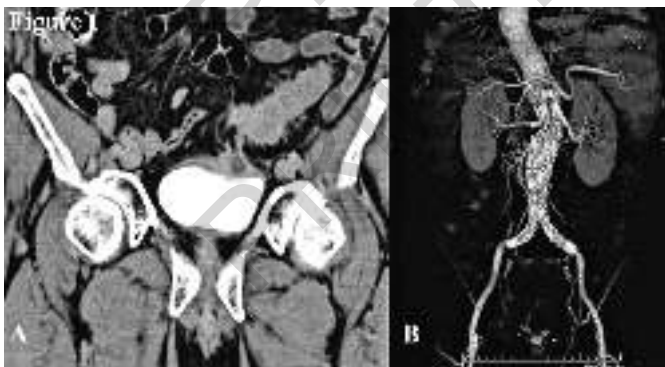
CT-scan of the abdomen showing a sigmoido-vescical fistula 18 days after laparoscopic lavage/drainage (LALA) of Hinchey III perforated diverticulitis (A). Ct-scan control of endovascular exclusion + renal chimney grafts for an interrenal aortic aneurysm performed 30 days after the endovascular procedure in the same patient, showing the correct morphology of the grafts and absence of endoleak (B).
